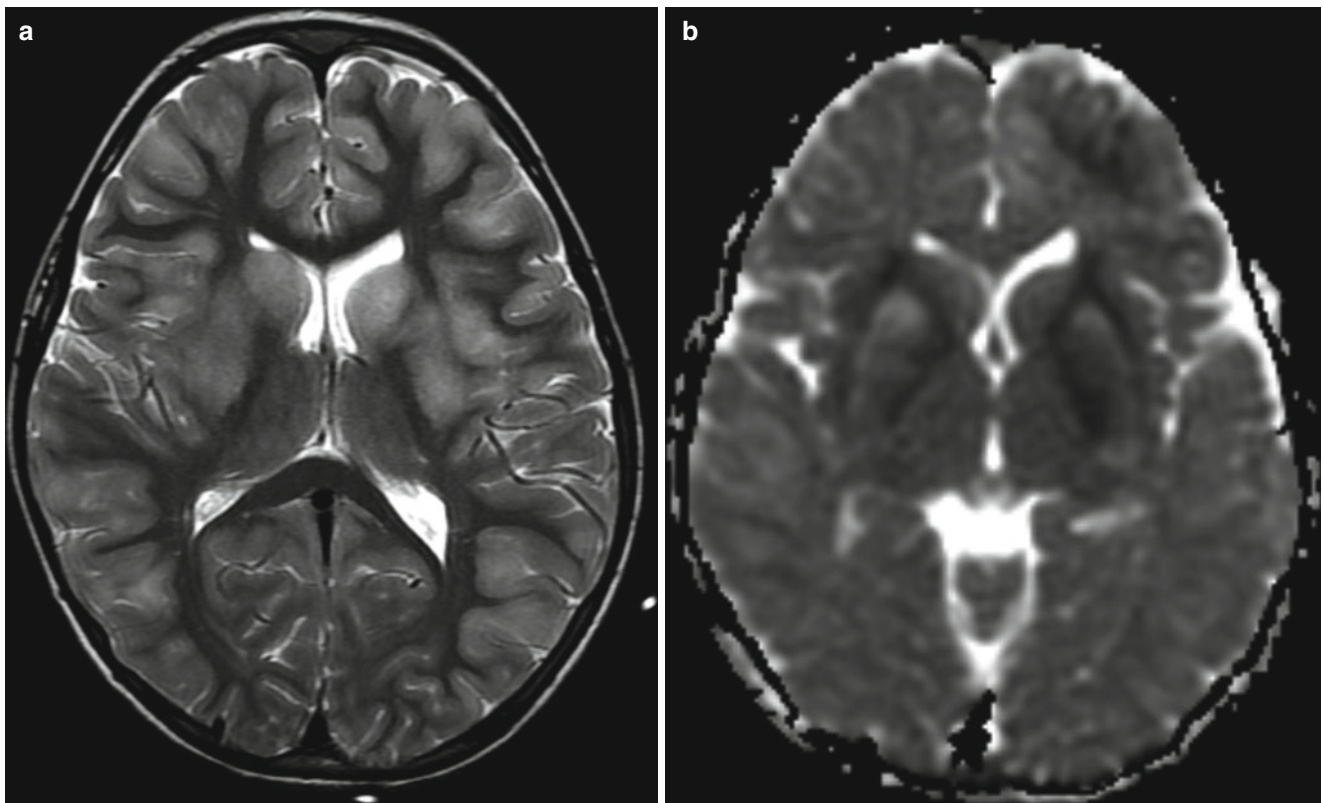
Varicella encephalitis. (a) T2-weighted image shows disseminated lesions in the cortex and the basal ganglia. (b) Diffusion image shows restricted diffusion of the lesions
